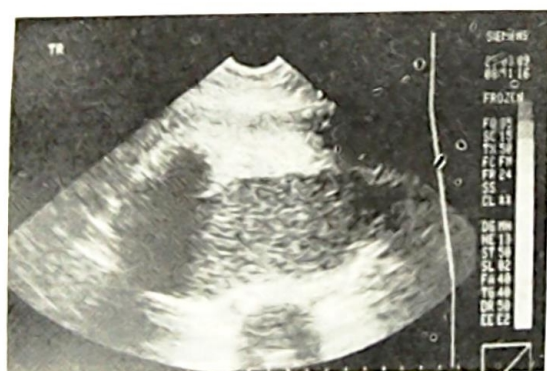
(Case 6): Ultrasound showing mixed echoes: An upper brightly echogenic area and a lower hypoechoic lower zone demarcated by an interface, above which there is a nodule with posterior acoustic shadowing "ice-berg" sign. This ultrasonic appearance appears inverted when compared to the CT scan in Fig. 5.
